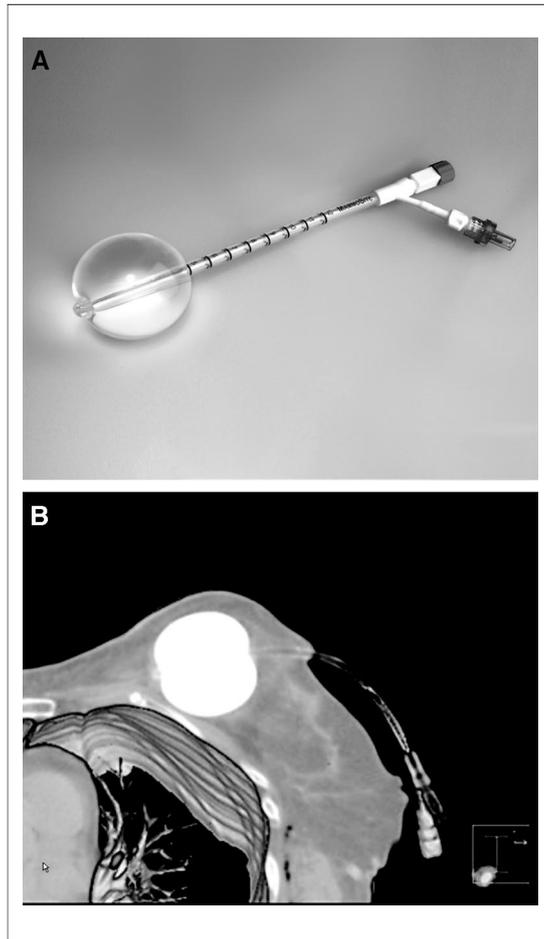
A, The Mammosite balloon-based catheter device. B, A computed tomography scan of the balloon inflated with sterile saline. Photos courtesy of Mammosite.
